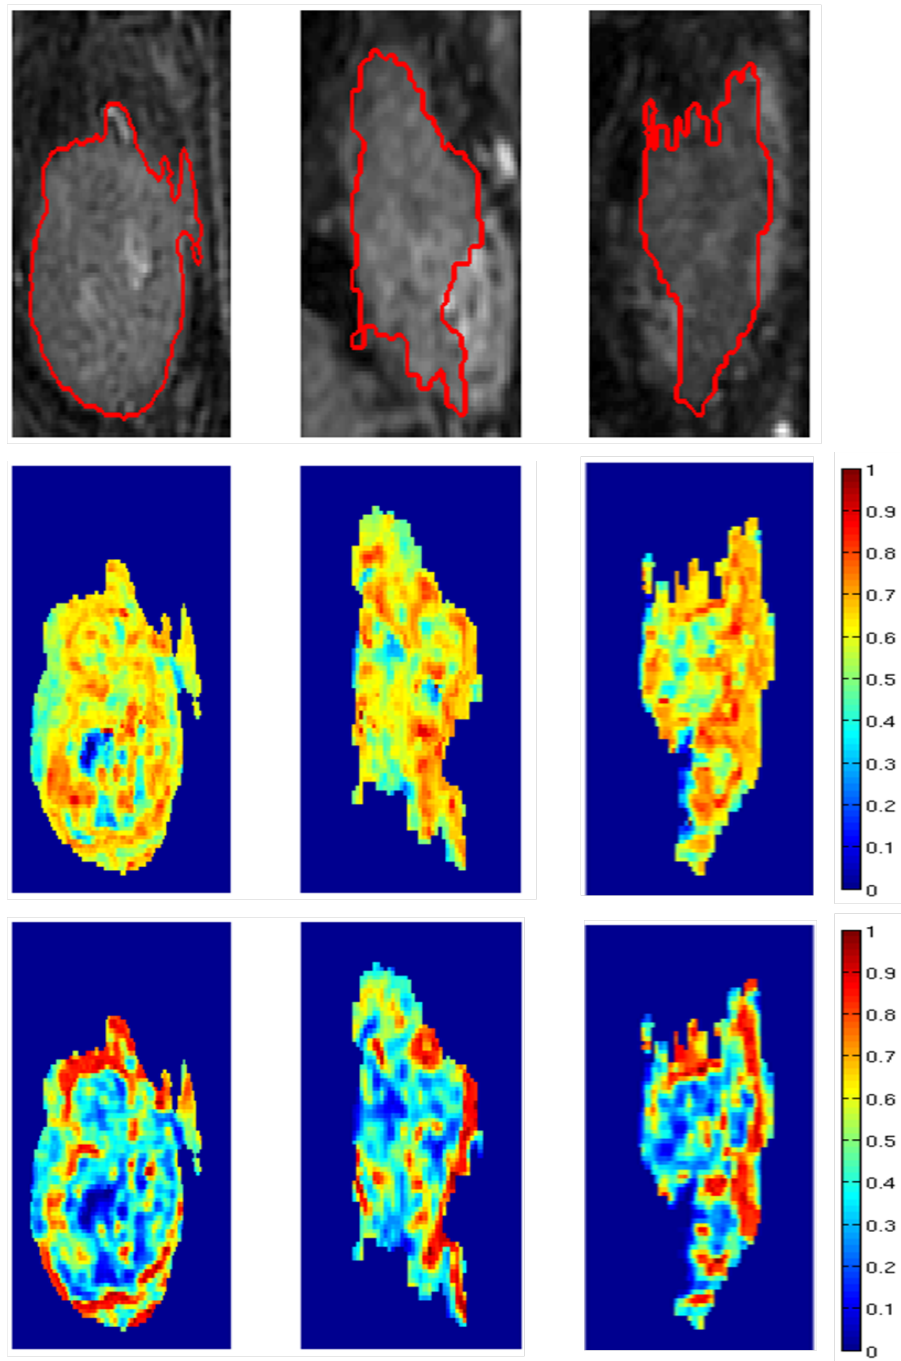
The tumour outline on the pre-contrast DCE-MRI image (top), the K^{trans} map (middle) and a ratio of the K^{trans} map with the map of onset times (bottom) for a rectal adenocarcinoma of a responding patient.
